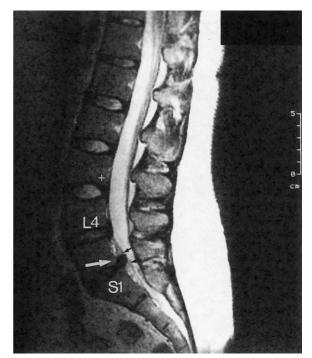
An MRI T2-weighted sagittal lumbar spine scan showing the moderately large central disc protrusion at the L5–S1 level (white arrow) that may be confined by the posterior longitudinal ligament which is displaced posteriorly. The moderately severe degree of compression on the anterior aspect of the dural tube/thecal sac is clearly visible (black arrows). Note that the L5–S1 intervertebral disc shows more advanced desiccation than does the L4–5 disc. (From Giles 2003.)
